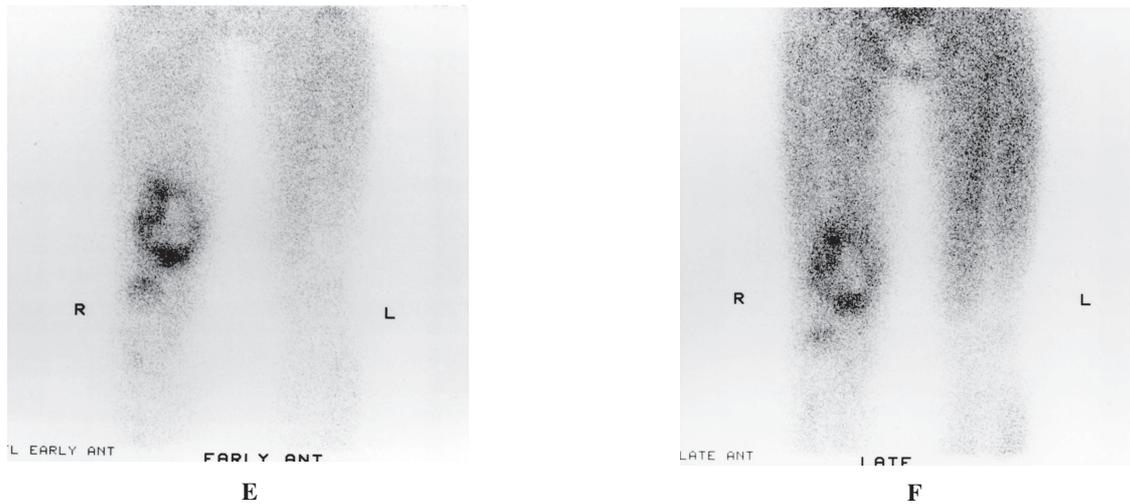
A: Radiograph demonstrates longitudinal linear striations in the distal end of the femur and the proximal end of the tibia bilaterally (*arrows*). Also noted is tumor shadow in the distal end of right femur (*arrowheads*). B: Sagittal T2-weighted MR image shows a large mass with bone marrow and soft tissue invasion. C: Sagittal gadolinium-enhanced T1-weighted MR image shows heterogeneous enhancement. D: ^{99m}Tc HMDP shows abnormal accumulation in the distal diaphysis of the right femur and the right patella. E: ^{201}Tl chloride scintigraphy demonstrates increased uptake in the distal end of the right thigh in the early phase. F: ^{201}Tl chloride is insufficiently washed out in the late phase.
